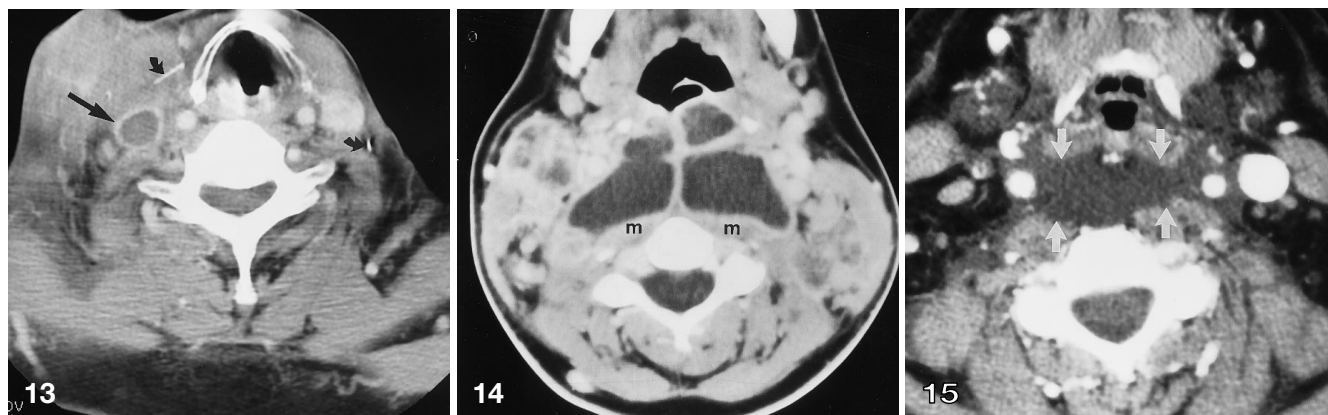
A contrast-enhanced CT scan was obtained in an intravenous drug user who complained of fever and neck swelling and tenderness. There is marked edema of the right sternocleidomastoid muscle, and inflammatory changes in adjacent soft tissues. The thrombosed right internal jugular vein (*straight black arrow*) demonstrates low density in the vascular lumen and enhancement of the surrounding wall. Several linear metallic densities (*short curved arrows*) represent needle fragments
